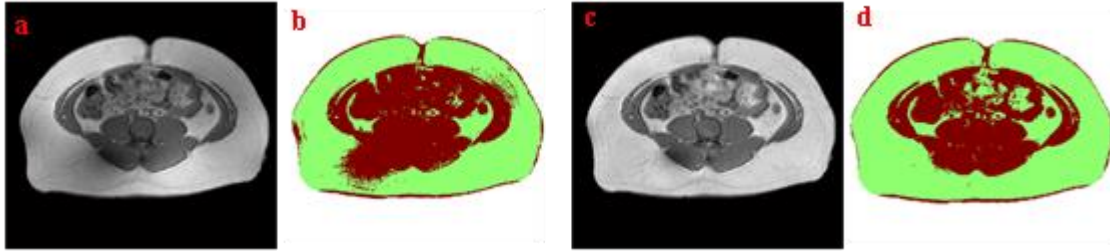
(a) MRI slice after region growing, (b) clustered result based on (a), (c) Intensity corrected image, and (d) clustered result based on (c)
